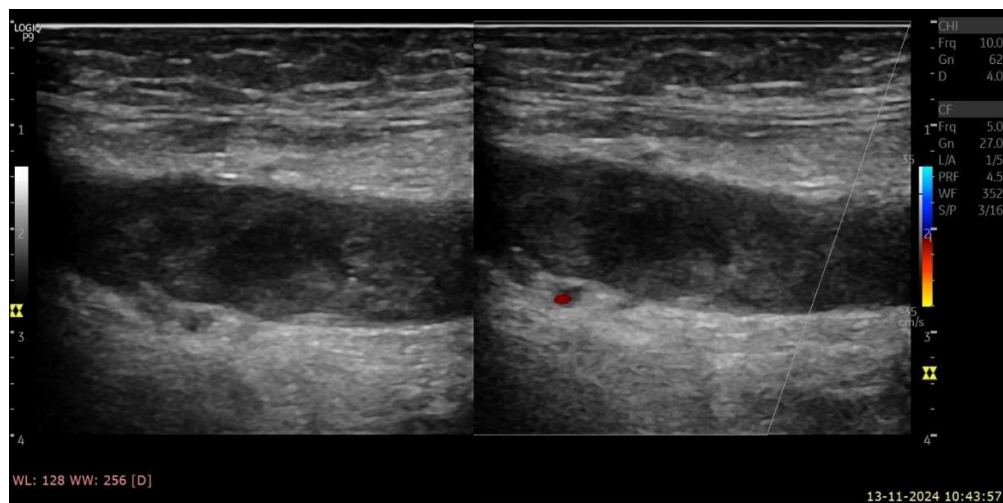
Colour Doppler image of the left common femoral vein showing absent/reduced flow signal in the thrombosed segment, confirming venous occlusion.
